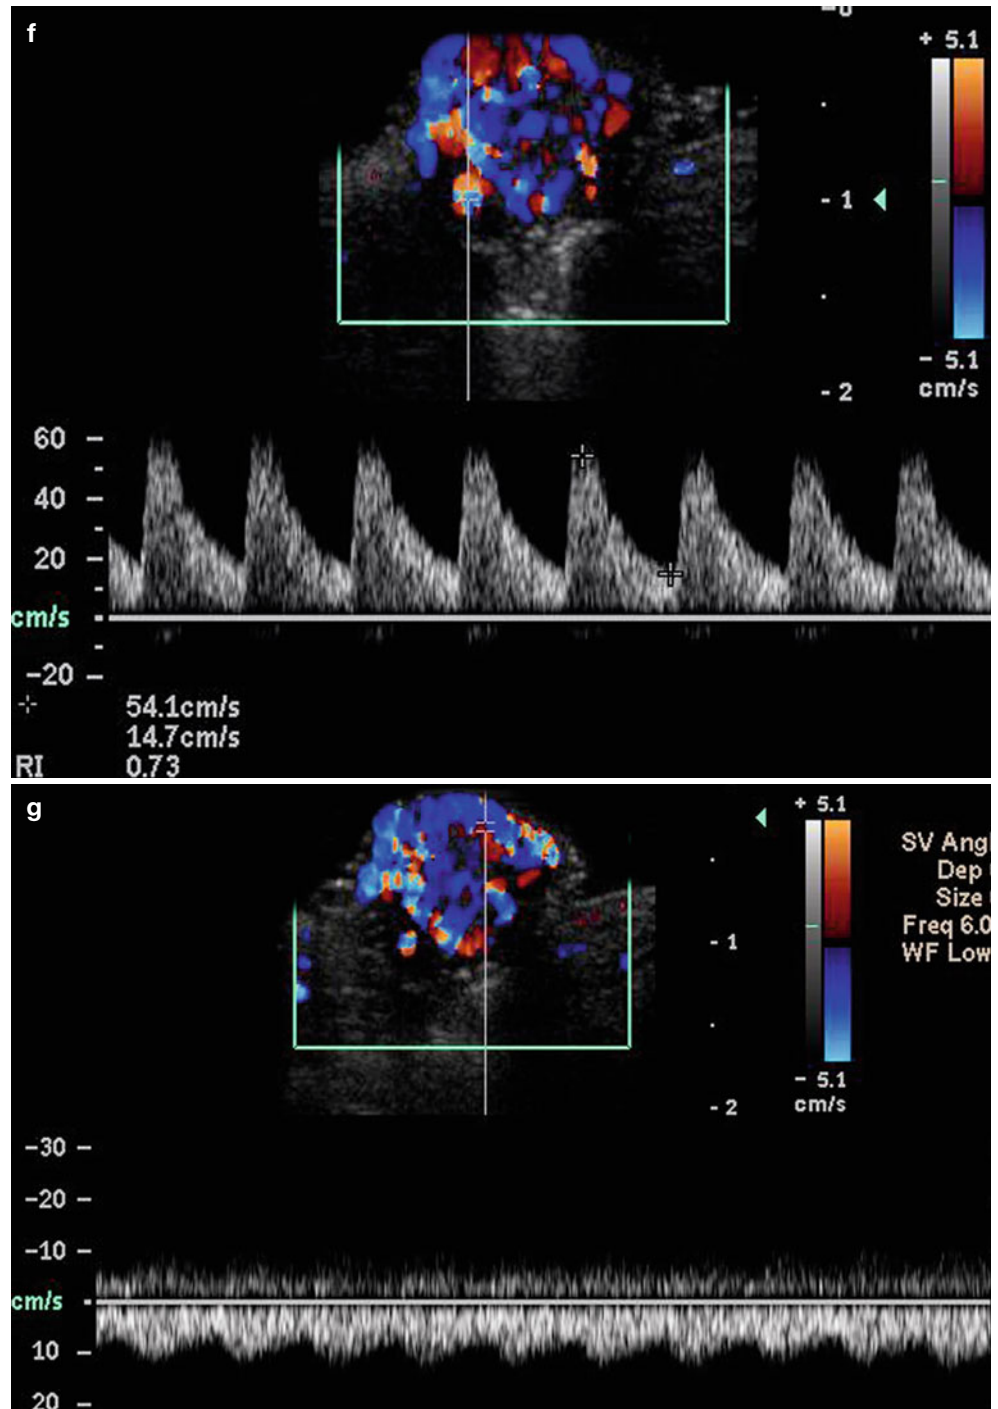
(a–g) Hemangioma (proliferative phase) (a) Clinical lesion shows erythematous swelling in the upper lip. (b) Grey scale ultrasound image (longitudinal view) demonstrates 1.39 cm long hypoechoic mass (*) in the upper lip that involves the cutaneous layers and the orbicularis muscle. (c) Grey scale ultrasound image (transverse view) shows 1.0 cm
